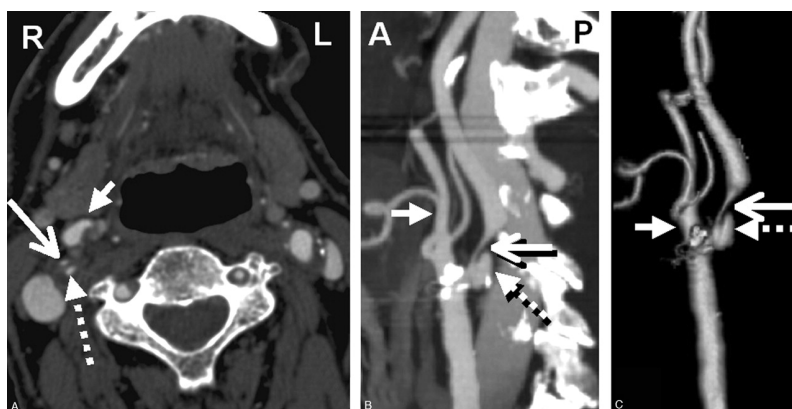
CTA showing right severe carotid bulb stenosis with deep plaque ulceration*
